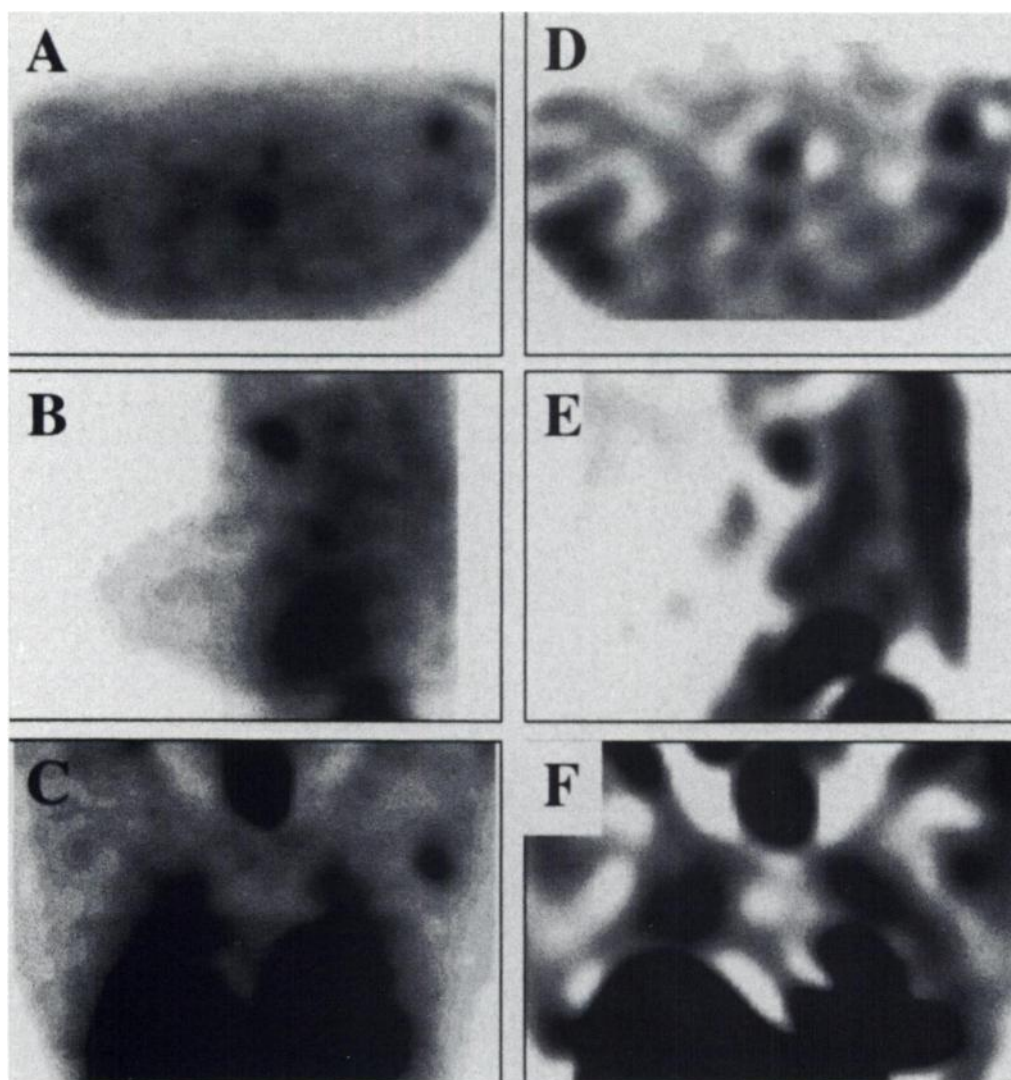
Axillary lymph node metastases. ISA-SPECT (A = transverse, B = sagittal, C = coronal slice orientations) clearly demonstrated high intense focal sestamibi accumulation. This finding was also displayed on transverse (D), sagittal (E) and coronal (F) slices of FBP-SPECT. Image quality of FBP-SPECT is inferior compared to ISA-SPECT.
